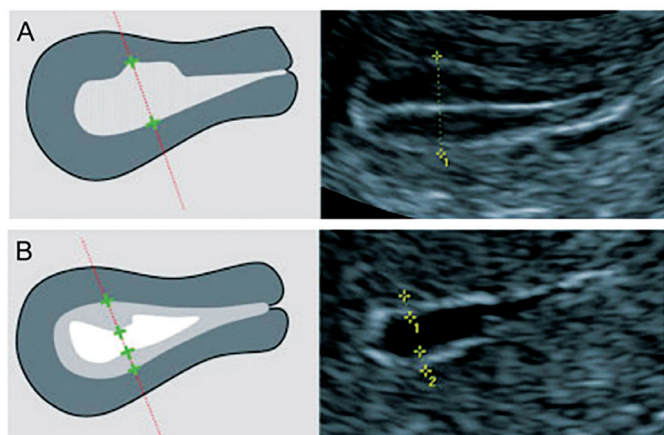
Evaluation of endometrial thickness using grayscale ultrasonography. Thick endometrium with a triple layer echogenic pattern is visible [21].
